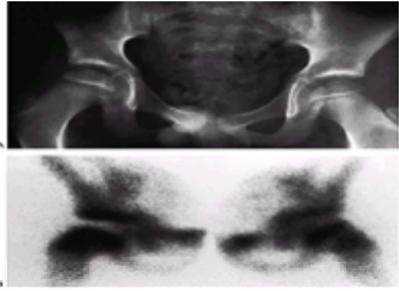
An 8-year-old boy with right hip pain. A: Anteroposterior radiograph demonstrates a slight increase in width and medial joint space; the femoral ossific nucleus is slightly smaller than the opposite side. B: Technetium 99 radionuclide scan demonstrates decreased uptake in the entire right femoral head, with increased vascularity in the neck.
